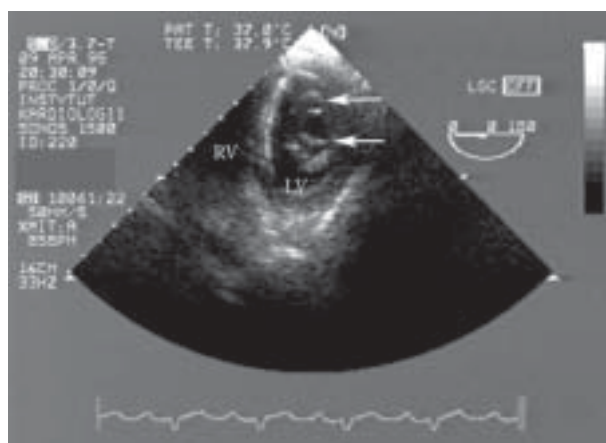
Transesophageal view showing duplicate double-orifice mitral valve (arrows); RV — right ventricle; LV — left ventricle
